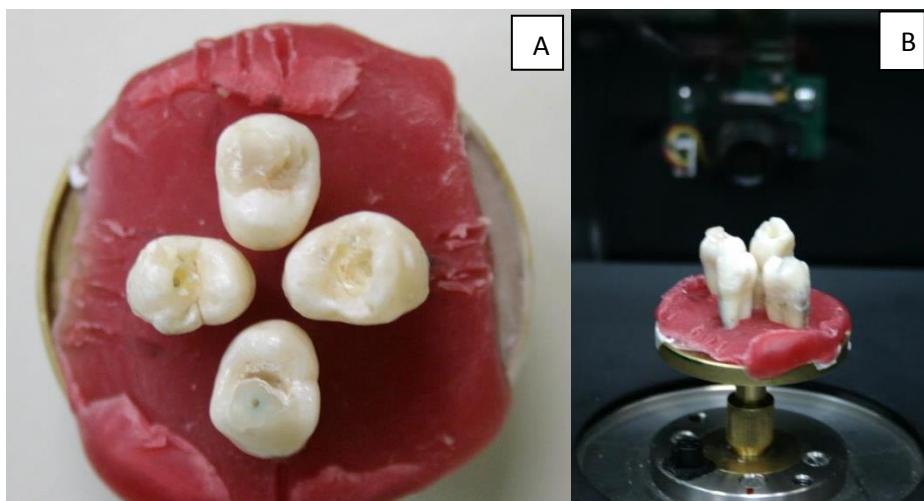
A- Espécimes montados na base giratória do scanner, B- Base giratória instalada no micro CT.
